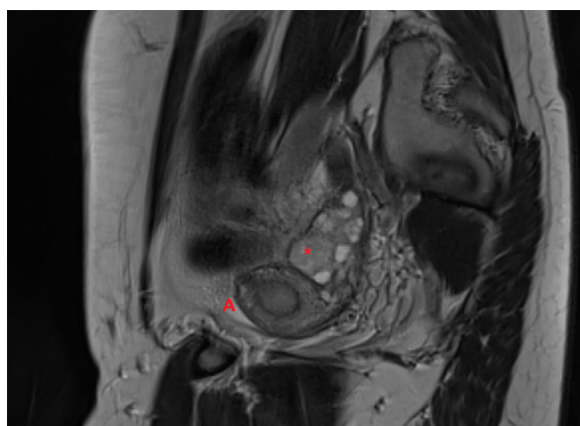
Sagittal view of Magnetic resonance image demonstrating the right noncommunicating horn (A) and right ovary (*).
